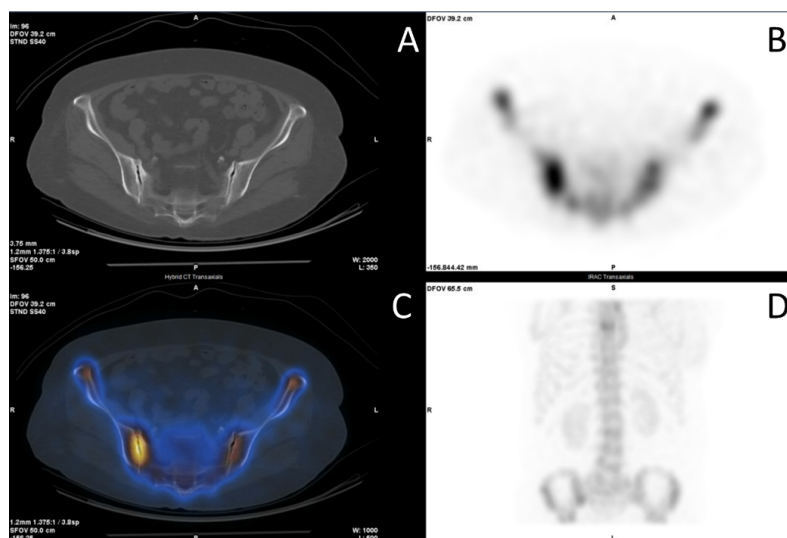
SPECT/CT of the sacroiliac joints showed focal increased uptake at the right side (B, C, D) with sclerosis (A). A: Axial CT, B: Axial SPECT, C: Axial fusion SPECT/CT, D: MIP. (Wasit Kanokwongnuwat)
